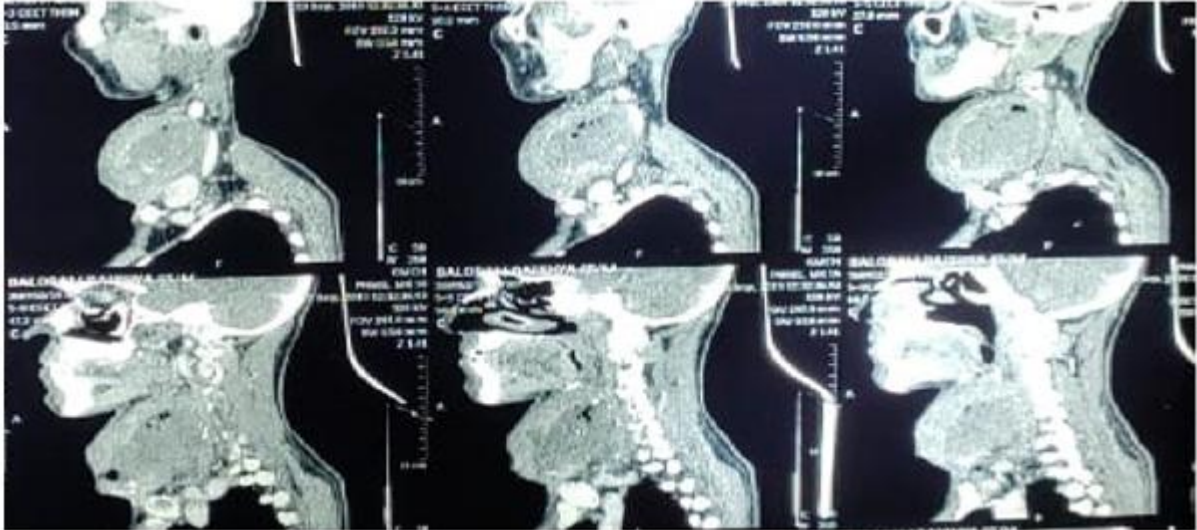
CT Scan showing thyroid swelling
